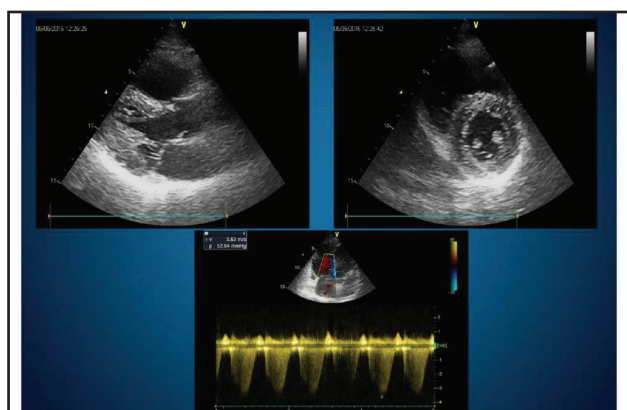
Echocardiogram performed at the time of admission
